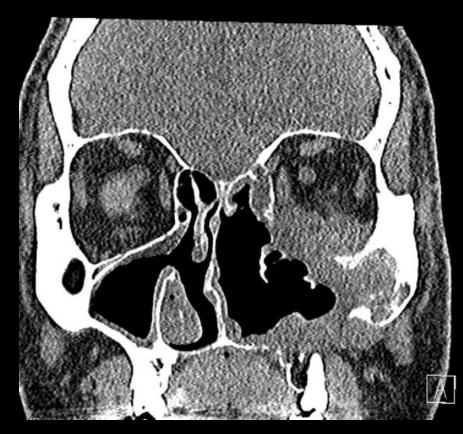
CT following sinonasal debridement
